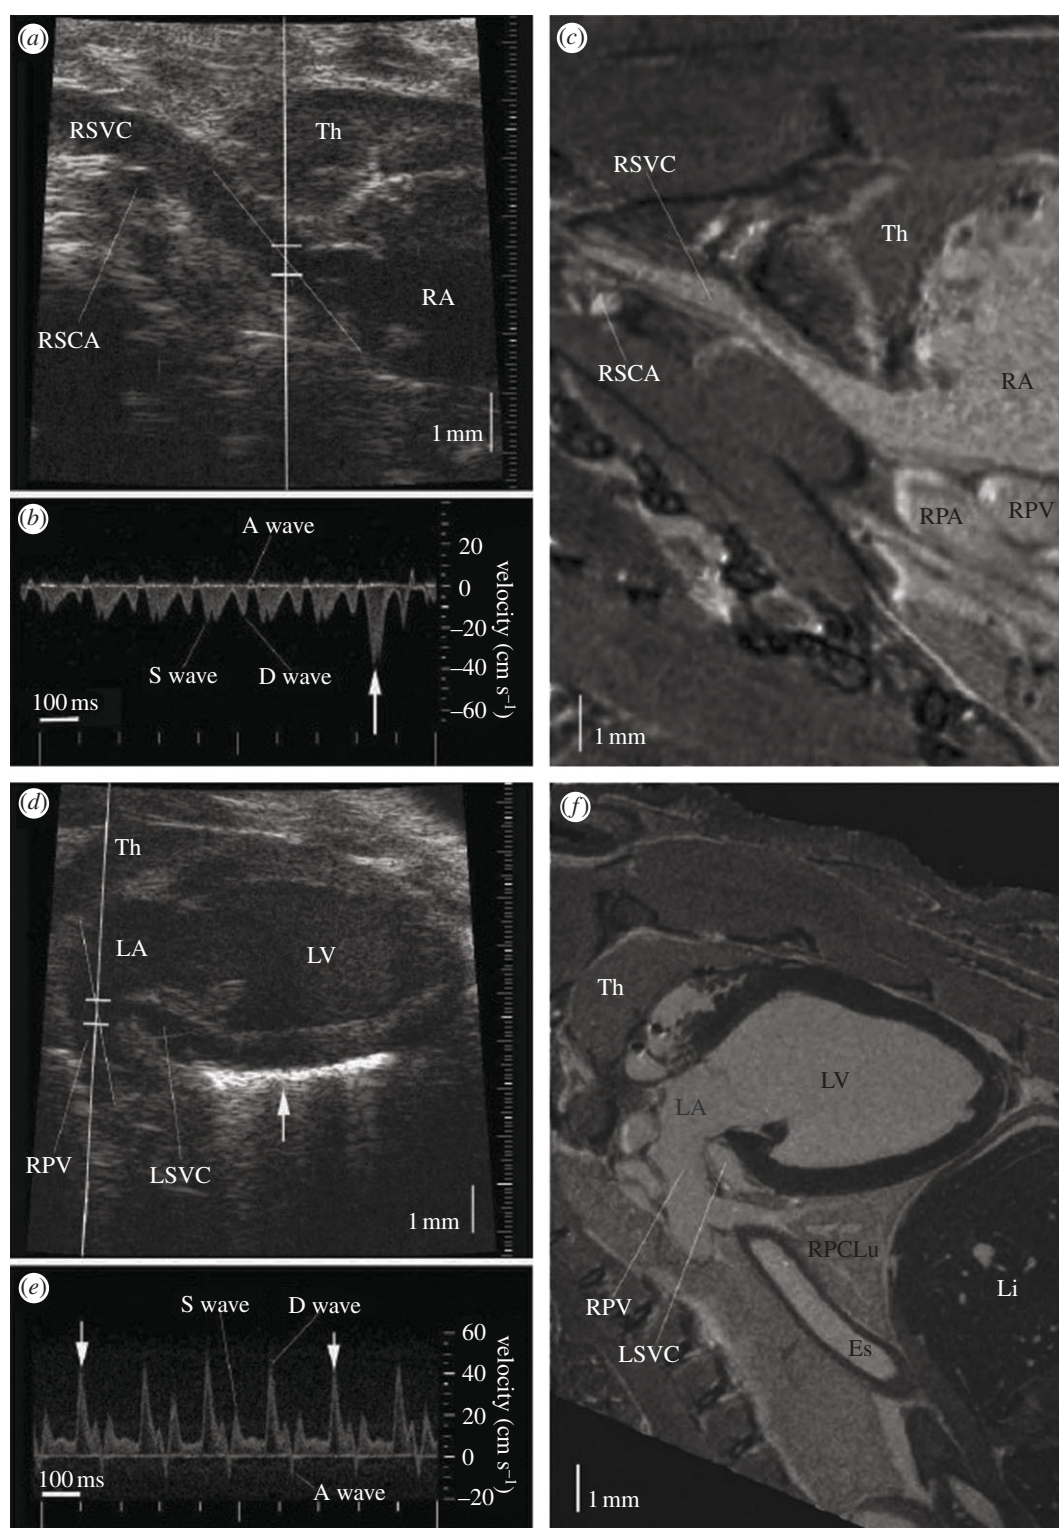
Micro-ultrasound imaging of the right and left atrial inflow channels, with anatomical confirmation by magnetic resonance (MR) imaging. (a) Image of a right parasternal longitudinal section. (b) The Doppler flow spectrum of right superior vena cava (RSVC), showing a small retrograde wave caused by atrial contraction. (c) MR image of a similar section to the micro-ultrasound image in (a), showing the vascular continuity from RSVC to the right atrium (RA), and the surrounding organs such as thymus (TH), right subclavian artery (RSCA), right pulmonary artery (RPA) and right pulmonary vein (RPV). (d) The micro-ultrasound image of a left parasternal longitudinal section showing the RPV, LA and LV, with the Doppler sample volume in the entrance of the RPV. (e) The Doppler flow spectrum from PV. The arrows indicate heart beats at the end of inspiration. (f) The MR image of a similar section to the micro-ultrasound image in (d). Adapted from [22].
